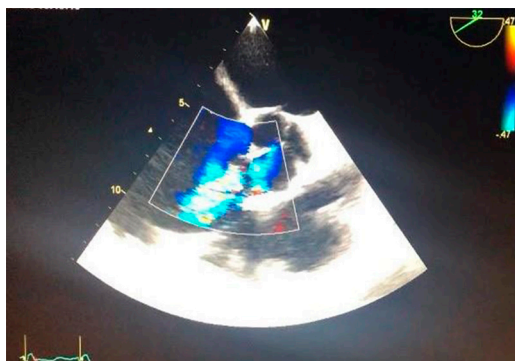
Ectransesophageal: Short axis. With color Doppler, a communication is observed between the ruptured right Valsalva sinus aneurysm and the right atrium.
